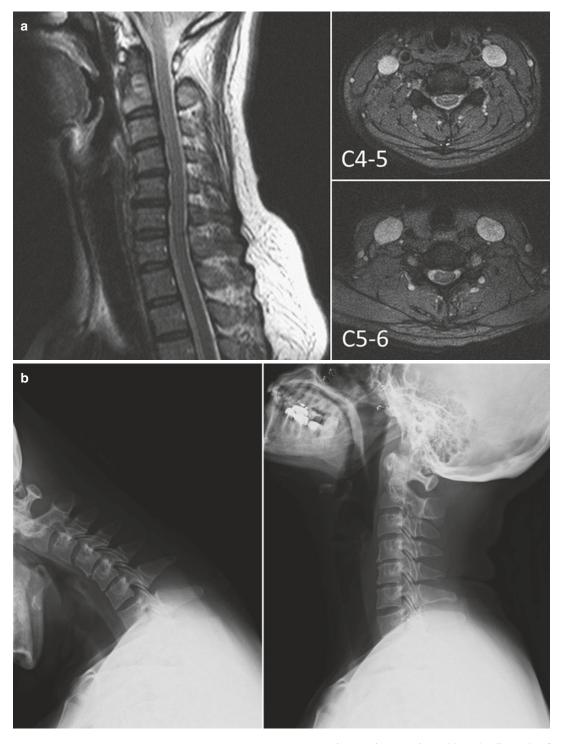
(a) Preoperative T2-weighted magnetic resonances images (MRI) demonstrated a herniated disc causing foraminal stenosis at C4–C5 and thecal sac compression at C5–C6. (b) The disc heights of C4–C5 and C5–C6 were decreased. However, the lateral flexion and extension radiographs demonstrated good segmental mobility throughout the subaxial cervical spine. (c) The
